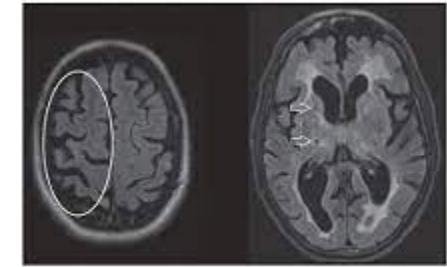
Axial T2-FLAIR sequences. Left image, asymmetrical cortical atrophy (circled) in a patient with corticobasal syndrome. Right image, hyperintense white matter changes and lacunar infarction (arrowed) in a patient diagnosed with vascular parkinsonism.
